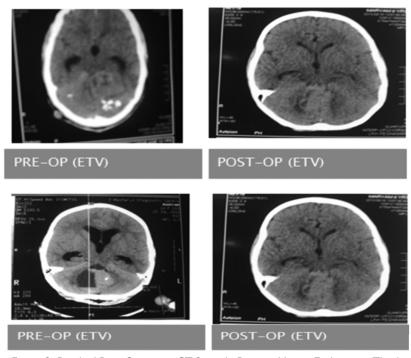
Pre And Post-Operative CT Scans In Patients Having Endoscopic Third Ventriculostomy (ETV) For Obstructive Hydrocephalus
